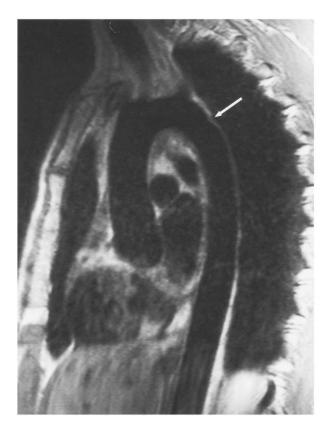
Magnetic resonance image obtained 1 year after primary surgical repair. *Arrow* indicates suture line.
